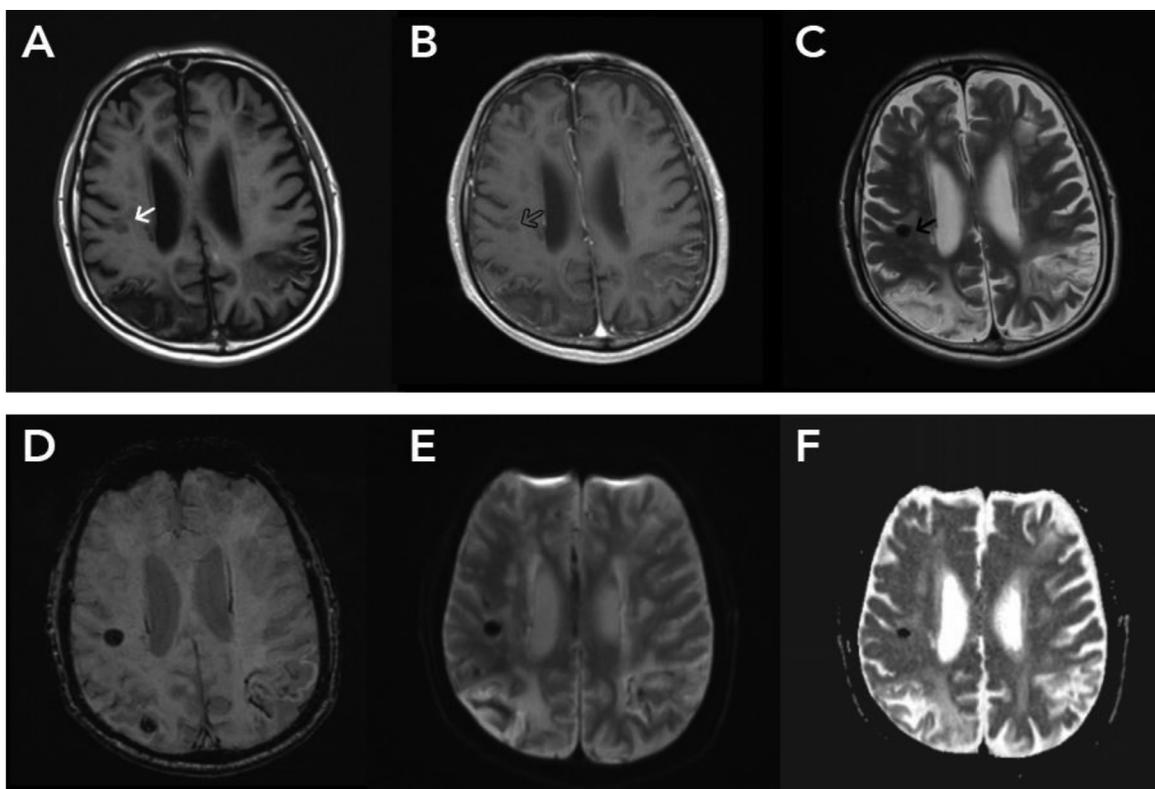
Nodular calcified stage at right subcortical parietal lobe seen on axial view T1-weighted image (A), Postcontrast T1-weighted image (B), T2-weighted image (C), SWI (D), DWI (E), and ADC (F) showing spherical lesions with well-defined border at right subcortical parietal lobe, diameter of 0.90 cm with hypointense on T1-weighted image (A, white arrow), no signal on T2-weighted image (C, black arrow), and blooming artefact on SWI (D). No restricted area was seen within the lesion on DWI and ADC (E, F).
